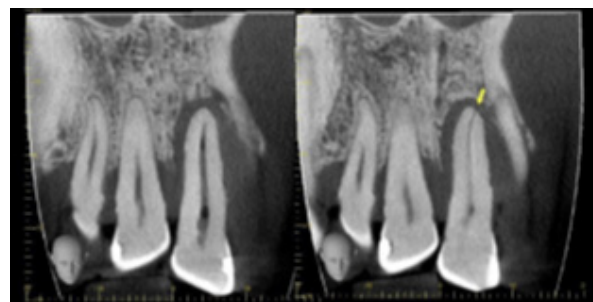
CBCT images of teeth.
